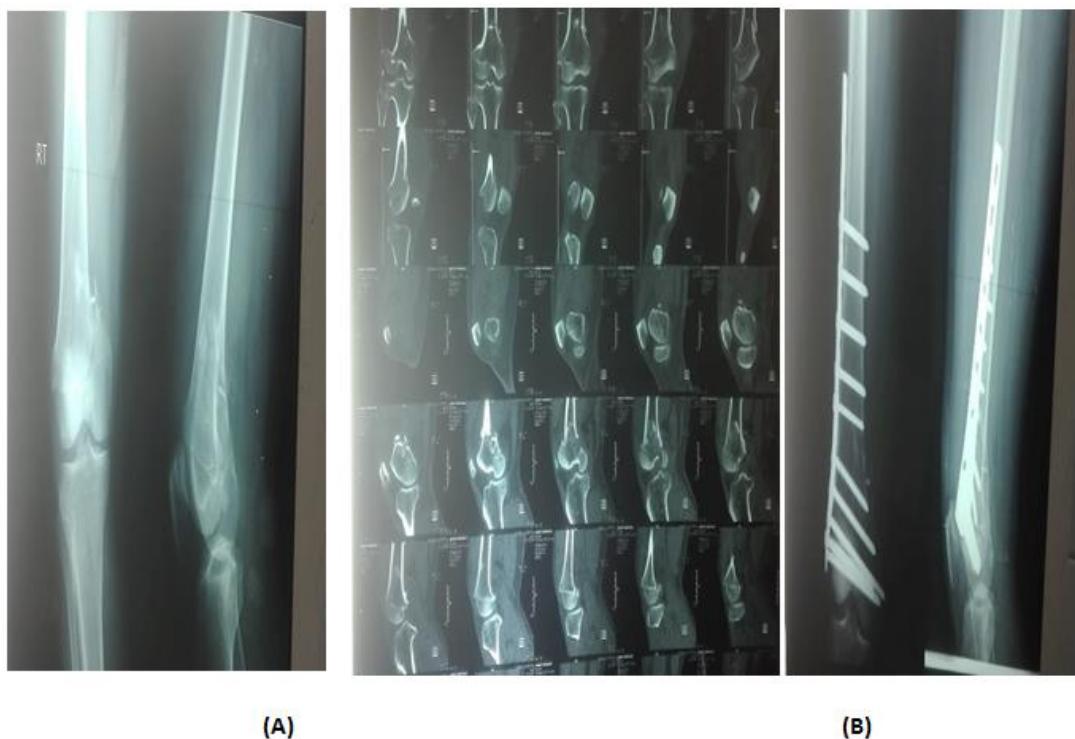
Male patient 40 years old with right supracondylar femur fracture type A2, single lateral technique (a) preoperative x-ray& CT, (b) postoperative x-ray
